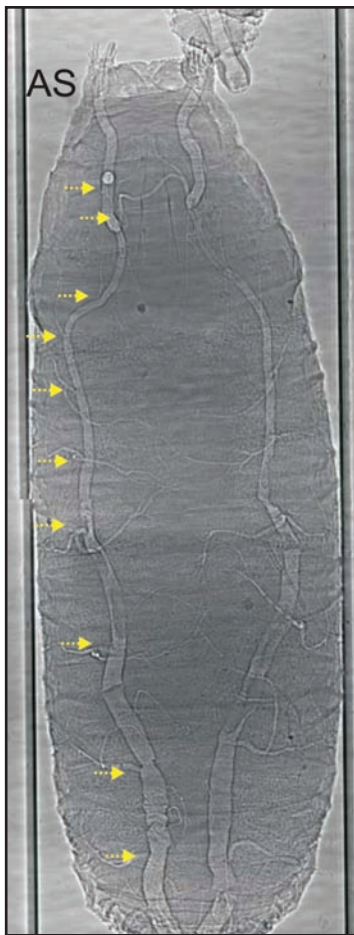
Synchrotron X-ray image of an Oregon-R white prepupa. Synchrotron X-ray imaging is based on density differences and provides a simple and rapid method for visualizing tracheae. Functional (i.e., air-filled) tracheae are easily distinguished from the surrounding tissues. In conjunction with fluorescent imaging, it should be possible to follow both the physical remodeling of the larval tracheae as they develop into the adult form and their gain of functionality when they are filled. In this image, the dorsal longitudinal tracheae run the entire length of a white prepupa, connecting the anterior spiracles (AS) with the posterior spiracles (out of the frame of the image). Ten nodes (arrows) are identified that correspond to branch points from which the secondary dorsal branches emerge (Hoshizaki DK, Merkey and Gibbs AG, unpublished).
